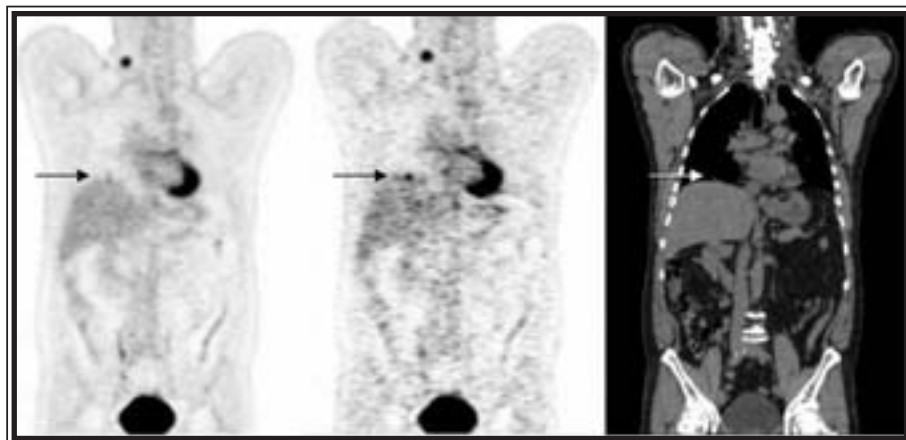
Example of the effect of respiratory gating on whole-body PET imaging. A: Standard whole-body PET image. B: One phase of the same study gated into seven respiratory phases. C: Corresponding CT image. Arrows indicate lesion with a volume of less than 1 cc.
